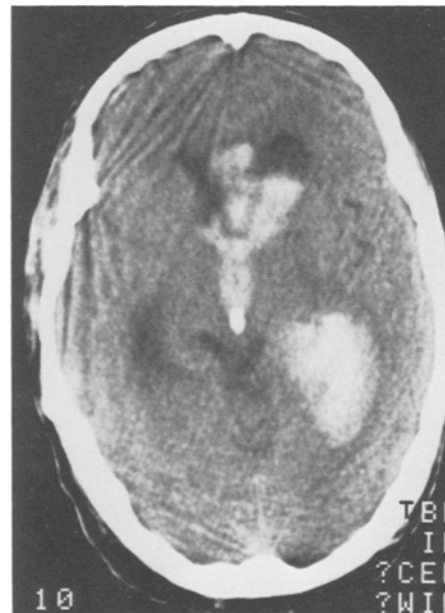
CT Scan showing large septal-callosal haemorrhage and intraventricular blood in the area of previous tumour radiation
